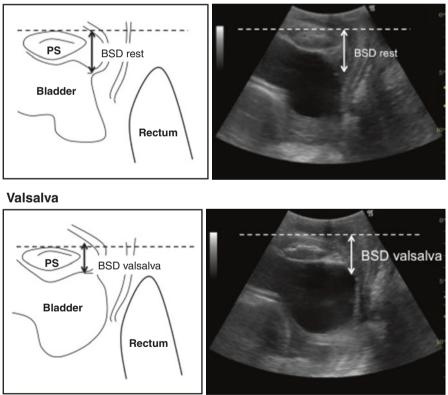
Ultrasound scan, bladder neck descent (Dietz measure). Bladder-Symphyseal Distance (*BSD*): the distance of the bladder neck relative to the horizontal line through the lower edge of the pubic symphysis (*PS*), at rest and during Valsalva (mm). Bladder Neck Descent (*BND*): difference between rest and strain (*BSD rest – BSD Valsalva*, mm) (Extract from: Deffieux X, Fatton B, Amarenco G, de Tayrac R. Manuel pratique d'urogynécologie, pages 37–52. Copyright © 2011 Elsevier Masson SAS. All rights reserved)
